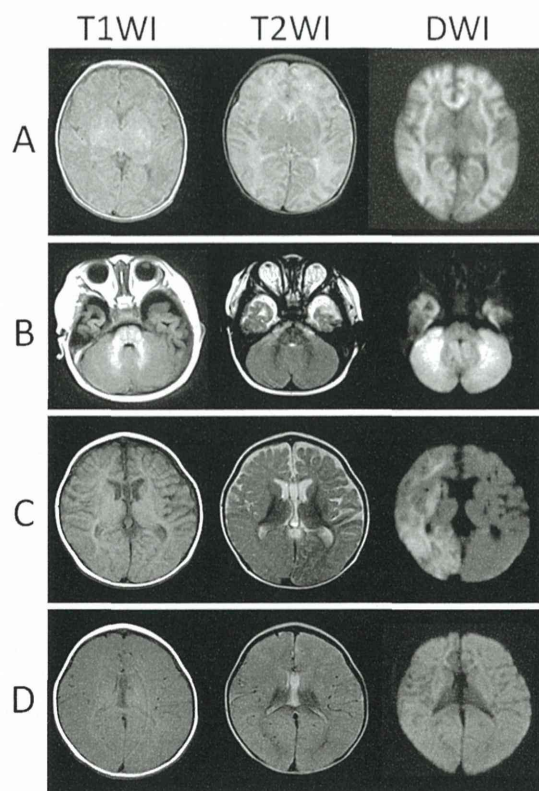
Head magnetic resonance imaging (MRI) of the patient. (A) At the age of 5 days, diffusion-weighted imaging (DWI) revealed high-intensity areas (HIAs) in the subcortical white matter, bilateral thalami, and basal nuclei. T1-weighted imaging (T1WI) and T2-weighted imaging (T2WI) showed no obvious abnormal findings. (B) At the age of 10 months, DWI revealed HIAs in the bilateral cerebellar hemispheres but not in the cerebral hemispheres. T1WI and T2WI showed no obvious abnormal findings. (C) At the age of 14 months, DWI showed diffuse HIAs in the right hemisphere and left frontal lobe at the time of symptom onset. (D) Two days later, the diffuse HIAs had enlarged into the bilateral hemisphere, excluding the thalami. T1WI and T2WI revealed a blurred cortical-white matter junction and diffuse cerebral edema.
